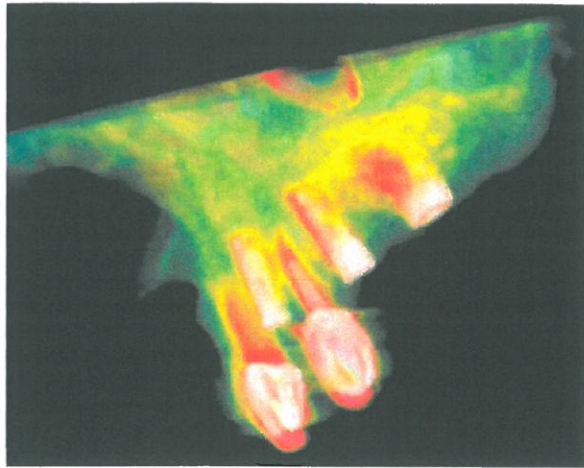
Maxilla (CT scan), dental implants (color indicates bone density: green low, amber medium, red high)
